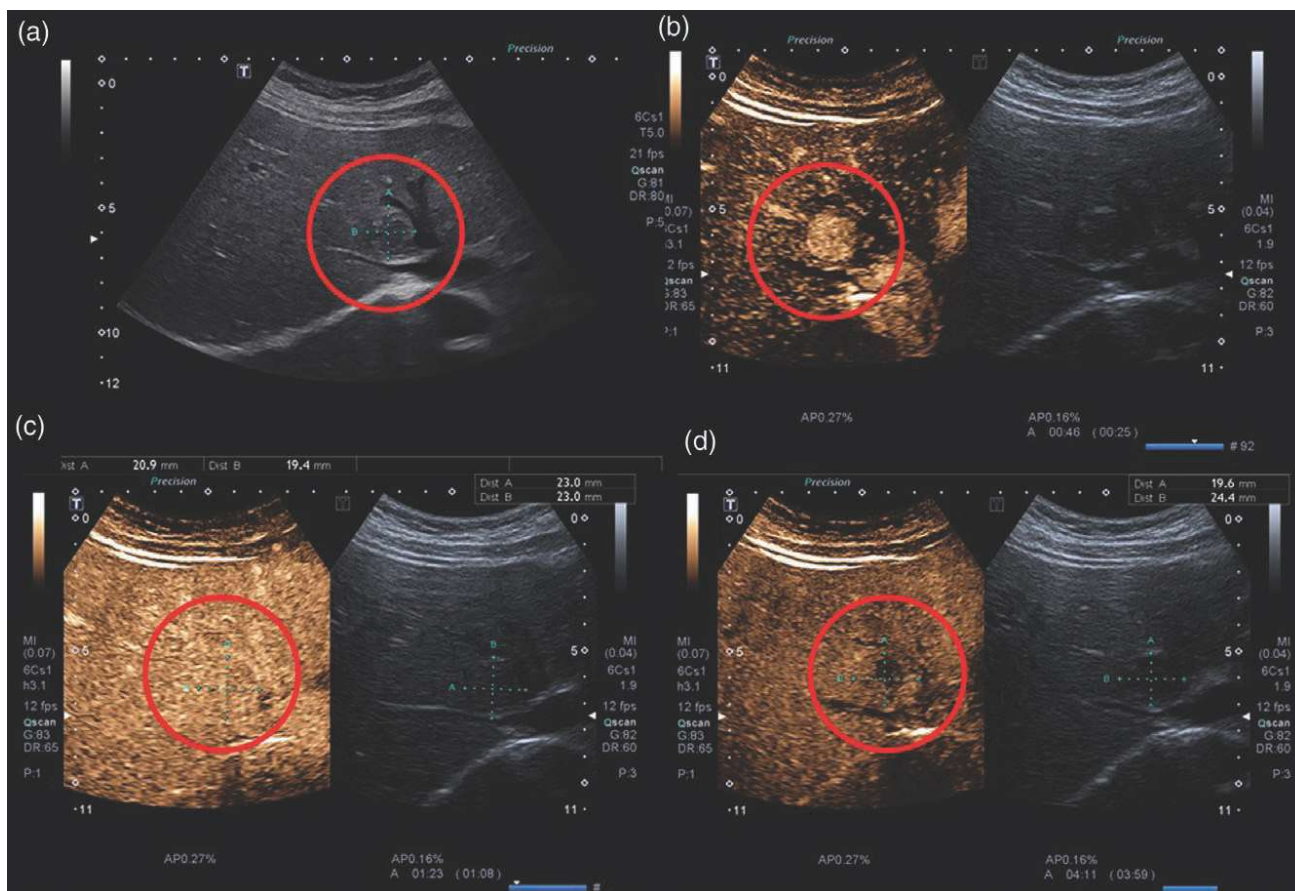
Typical example of an HCC in noncirrhotic liver. HCC in noncirrhotic liver. (a) B-mode ultrasound: isoechoic lesion of 2 cm. (b–d) CEUS. (b) arterial phase hyperenhancement, (c) iso-enhancement in the portal venous phase, (d) mild washout in the late phase. CEUS, contrast-enhanced ultrasound; HCC, hepatocellular carcinoma.
